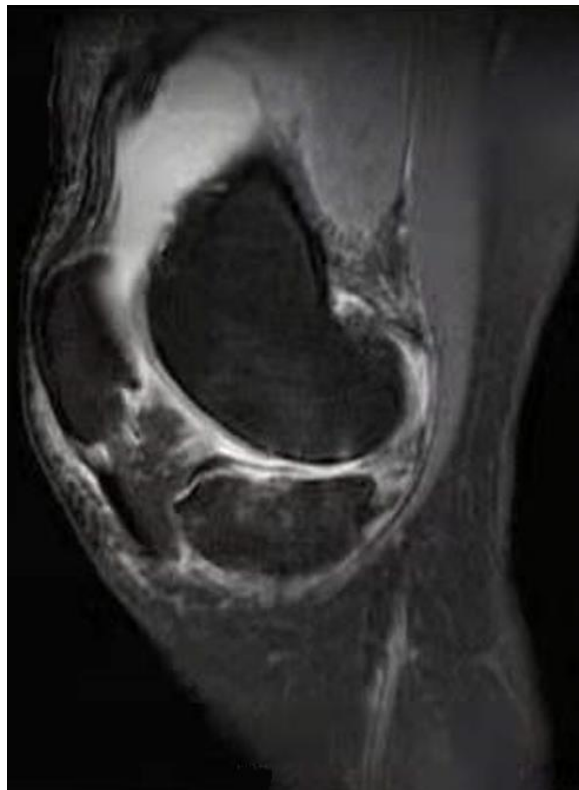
Magnetic resonance imaging of the right knee joint showing (T2) collection of fluid in the joint and soft tissue swelling.
